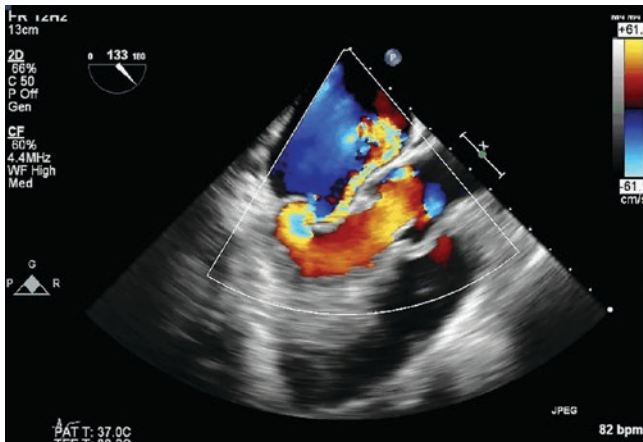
Highly eccentric jets may lead to underestimation of the degree of mitral regurgitation not only by color Doppler but also by the PISA method. In this figure, there is a flail posterior leaflet leading to a highly eccentric jet of severe mitral regurgitation. However, color Doppler appears to underestimate the severity of MR
